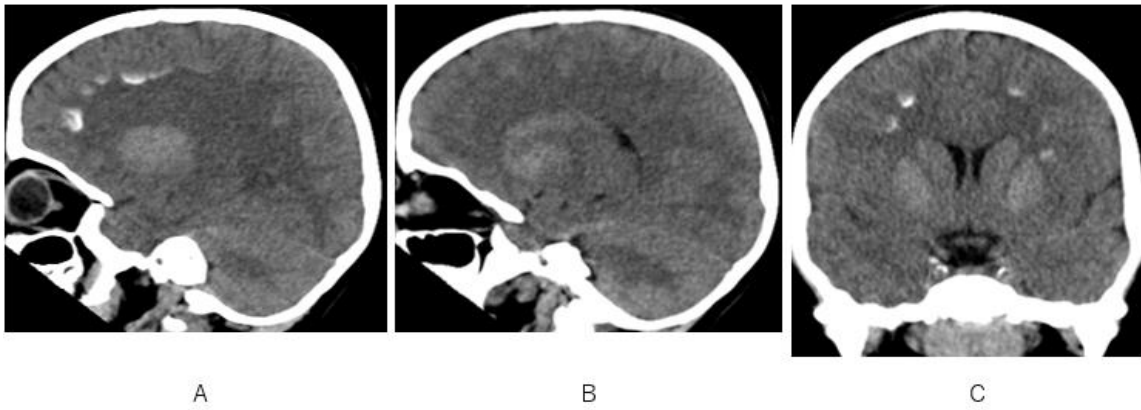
Sagittal (A, B) and coronal (C) CT images depict high attenuation areas of cortex adjacent to deep white matter in frontal lobe (A, C) and slight high attenuation of caudate nucleus and basal ganglion (A-C).
